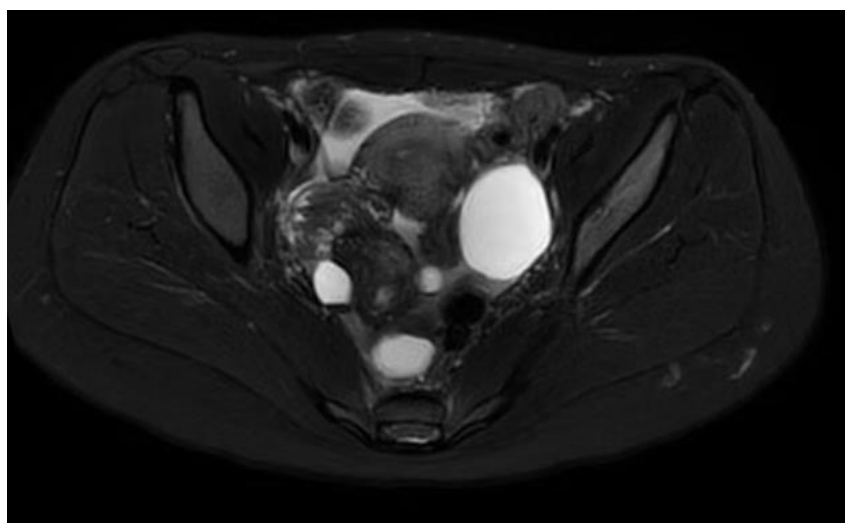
MRI coronal scan of the pelvis showing the right ovary cystic ovary torsion.
